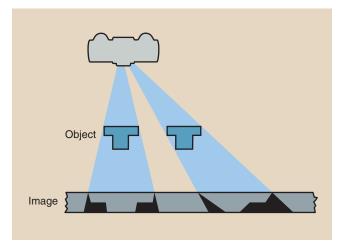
Irregular anatomy or objects such as these can cause considerable distortion when radiographed off the central ray.
